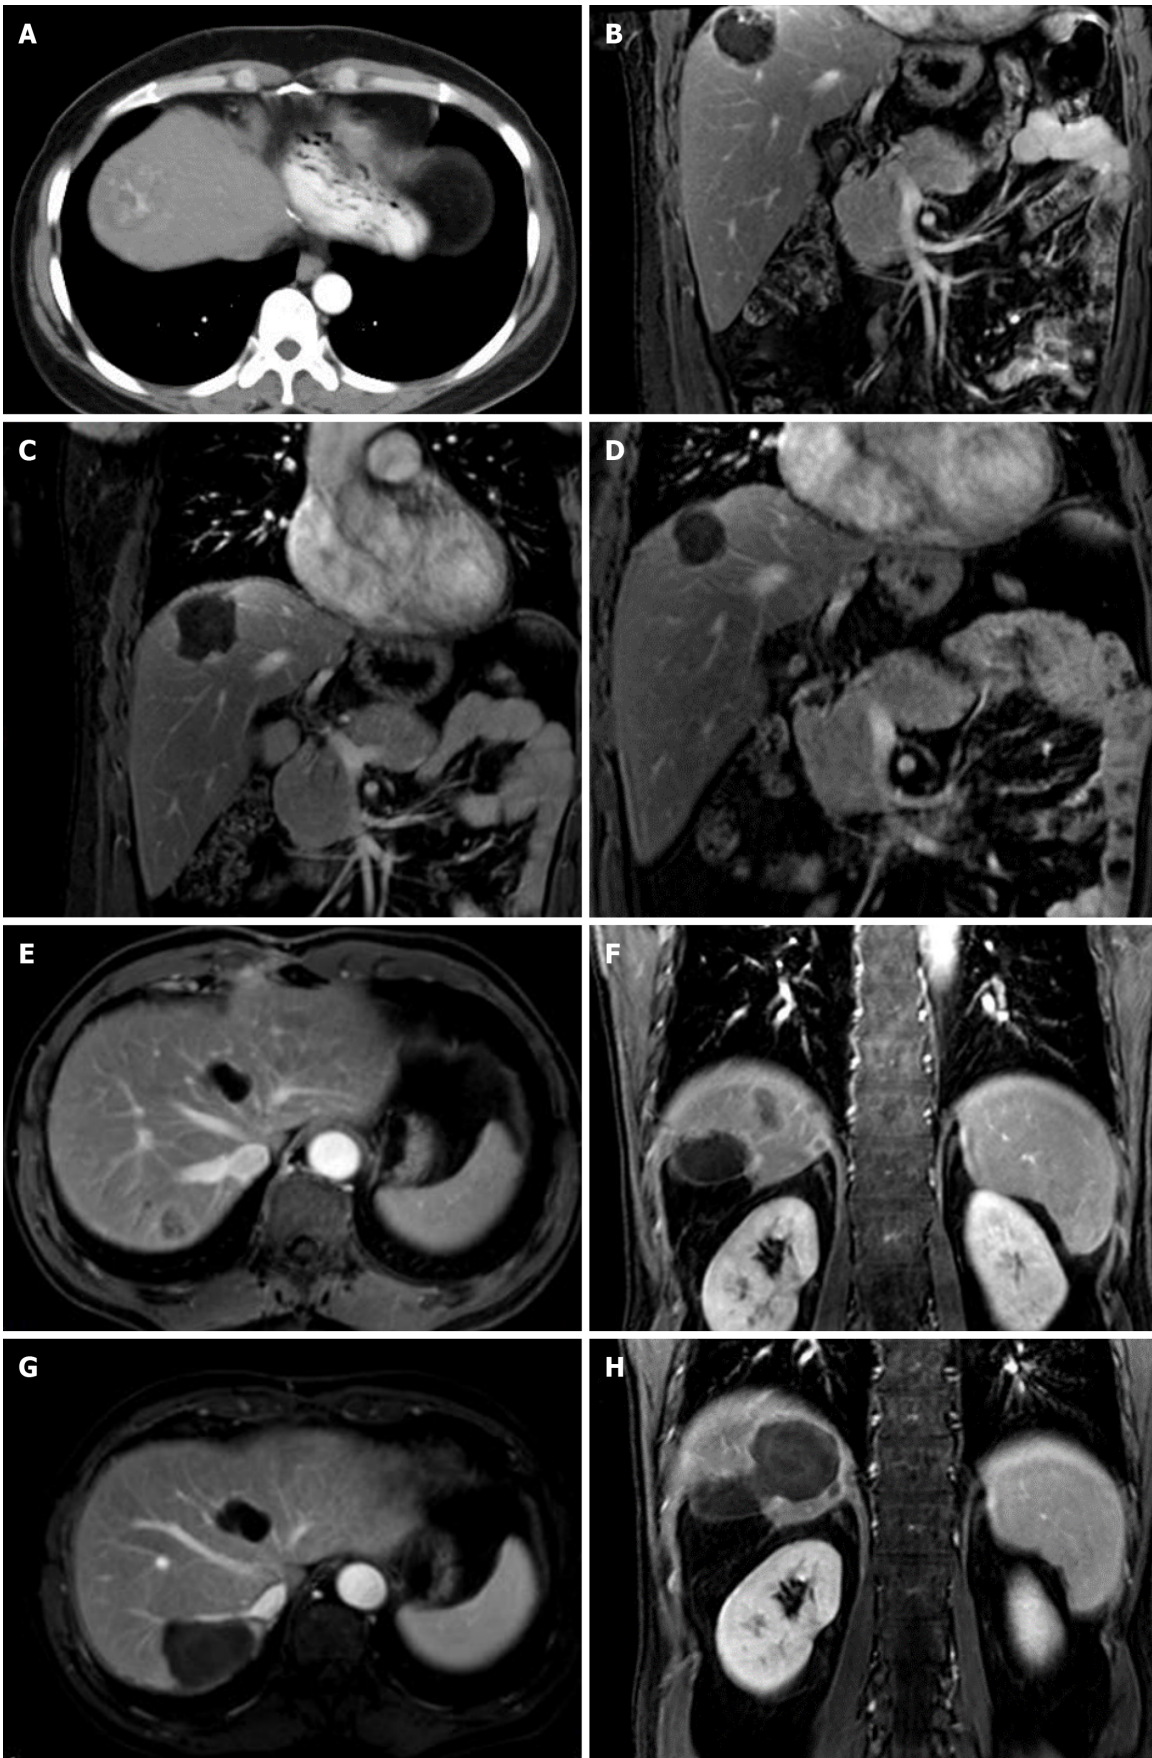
Two patients with cirrhosis and subphrenic hepatocellular carcinoma were treated with transarterial chemoembolization-microwave ablation. A-D: 50-year-old female with cirrhosis and subphrenic hepatocellular carcinoma measuring 5.0 cm in maximum diameter in segment 8 of the liver. Preprocedure axial contrast computed tomography shows a hypervascular tumor in the liver dome (A); coronal enhanced magnetic resonance imaging (MRI)
